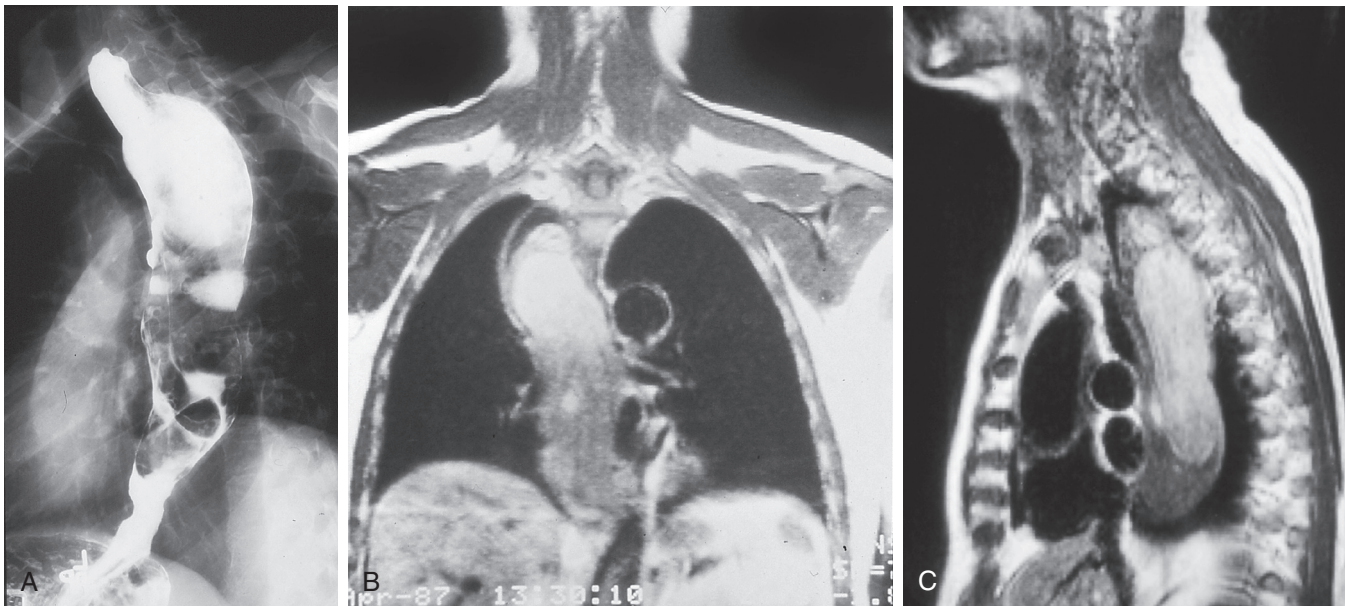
■ Fibrovascular polyp. A, A large polypoid filling defect of the intrathoracic esophagus is seen. B and C, Magnetic resonance image of tumor shows a large soft tissue mass filling the esophagus.
